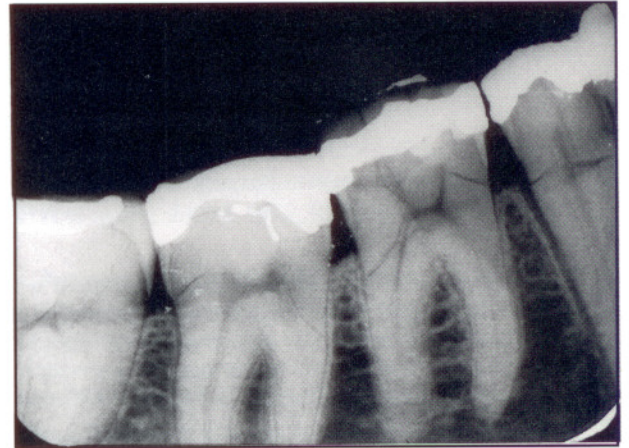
Postmortem periapical radiograph of the lower right segment of aircraft victim
